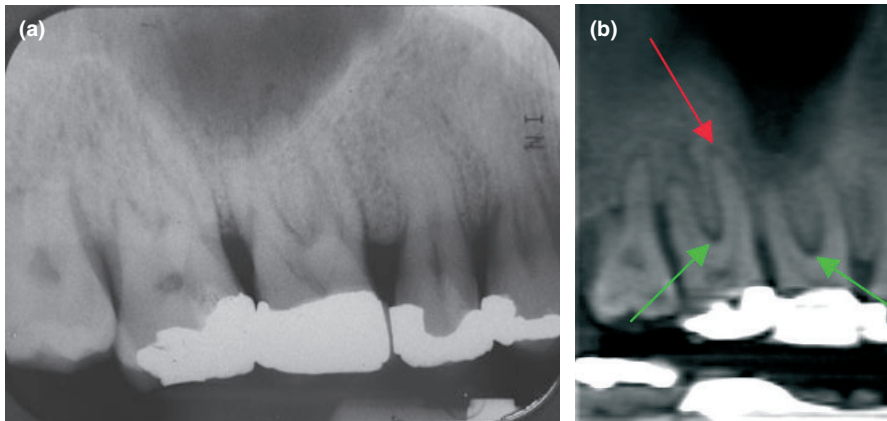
(a–b) This patient has undergone non-surgical periodontal treatment, the posterior teeth have not responded well to treatment, the patient was referred for an endodontic opinion of the maxillary right quadrant prior to periodontal surgery. (a) A periapical radiograph of the maxillary right quadrant was inconclusive. (b) CBCT sagittal slice reveals periapical radiolucencies (red arrows) associated with teeth 16 and 17, and furcation (green arrows) involvement.
